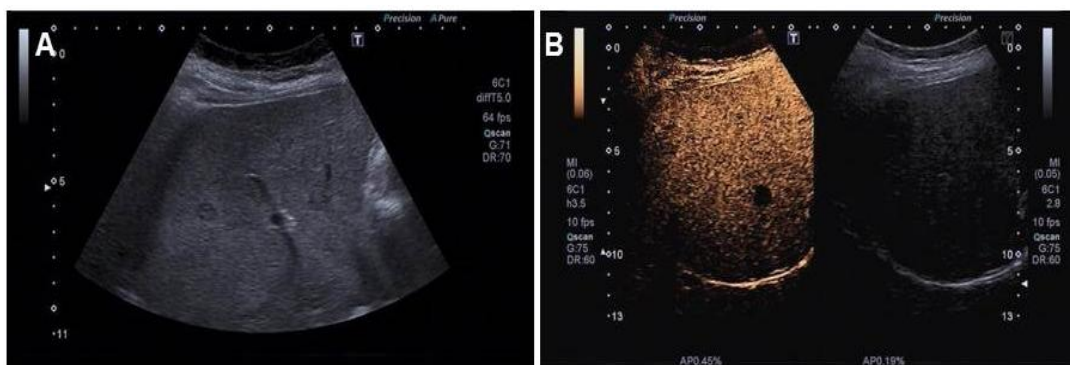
(A) Abdominal ultrasound and (B) contrast enhanced ultrasound (CEUS): Hypoechoic, round lesions in the right hepatic lobe with washout suggestive for malignancy in CEUS
